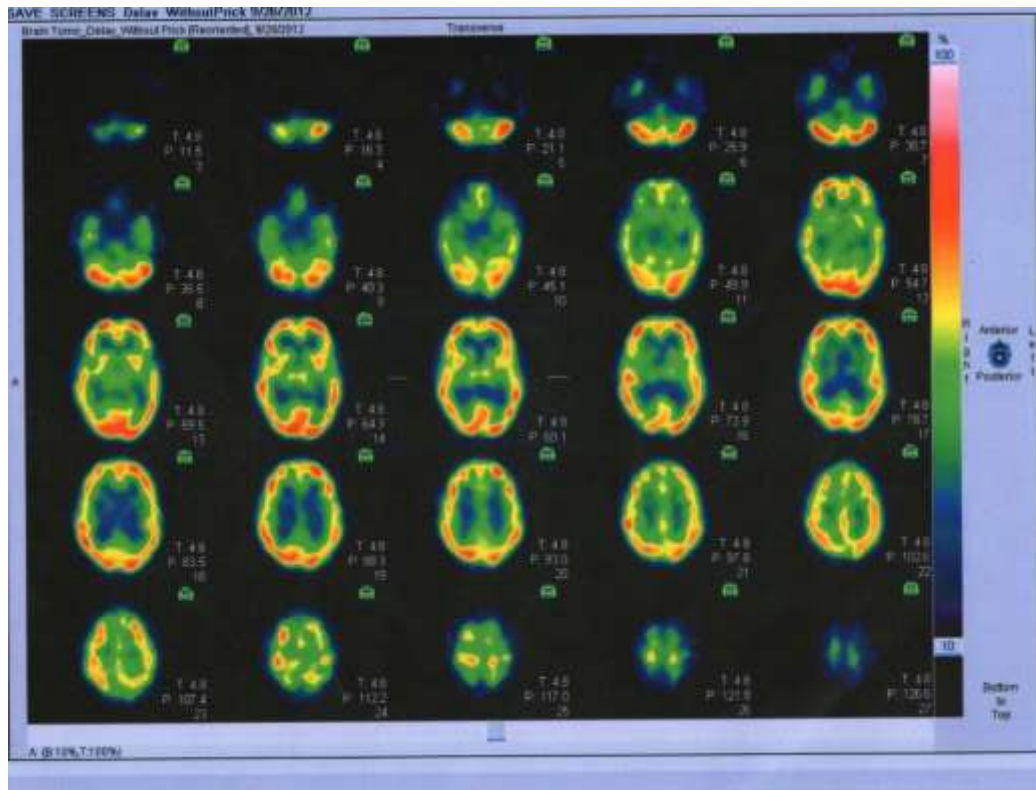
SPECT findings of female Subject during Clinical Remission
